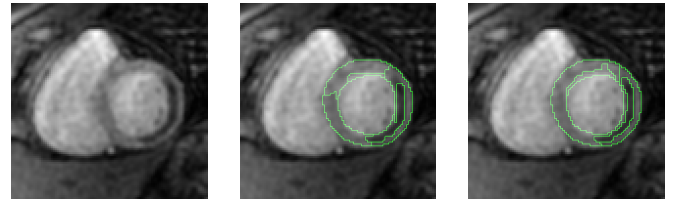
Segmentation of hypo-perfused regions inside the myocardium in MRI perfusion imaging using respectively the algorithm from [6] (second column) and our one (third column).
